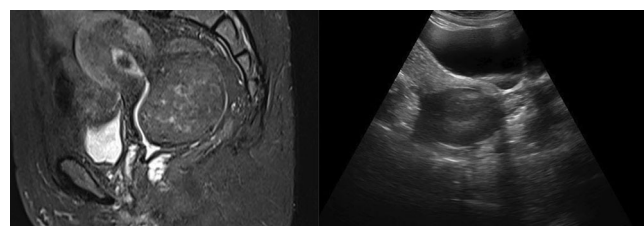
(A): FLAIR MRI sequence in a case of fibroid shows a predominantly hypointense mass arising from posterior wall of cervix and lower uterine cavity. Figure 1(B): Corresponding ultrasound image revealed a well-defined hypoechoic mass in posterior wall of lower uterine segment.
